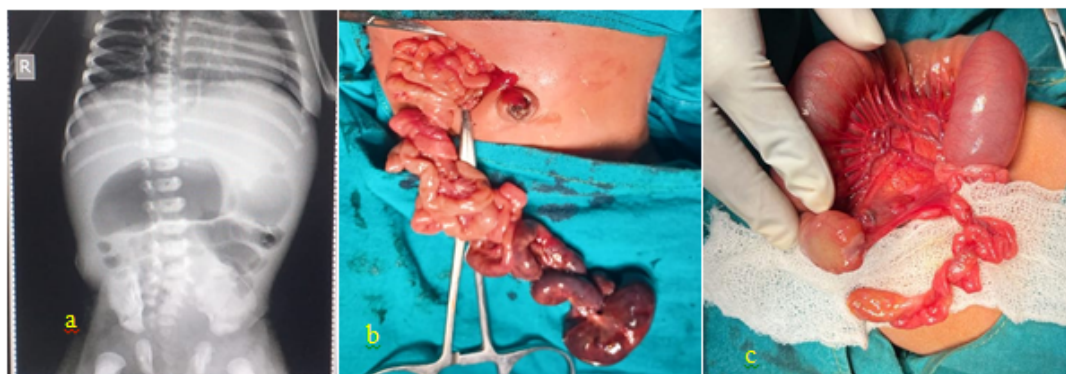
a: Abdominal x-ray showing triple bubble sign – suggestive of jejunal atresia, b- jejunal atresia with volvulus of ileum, c- apple peel ileal atresia
